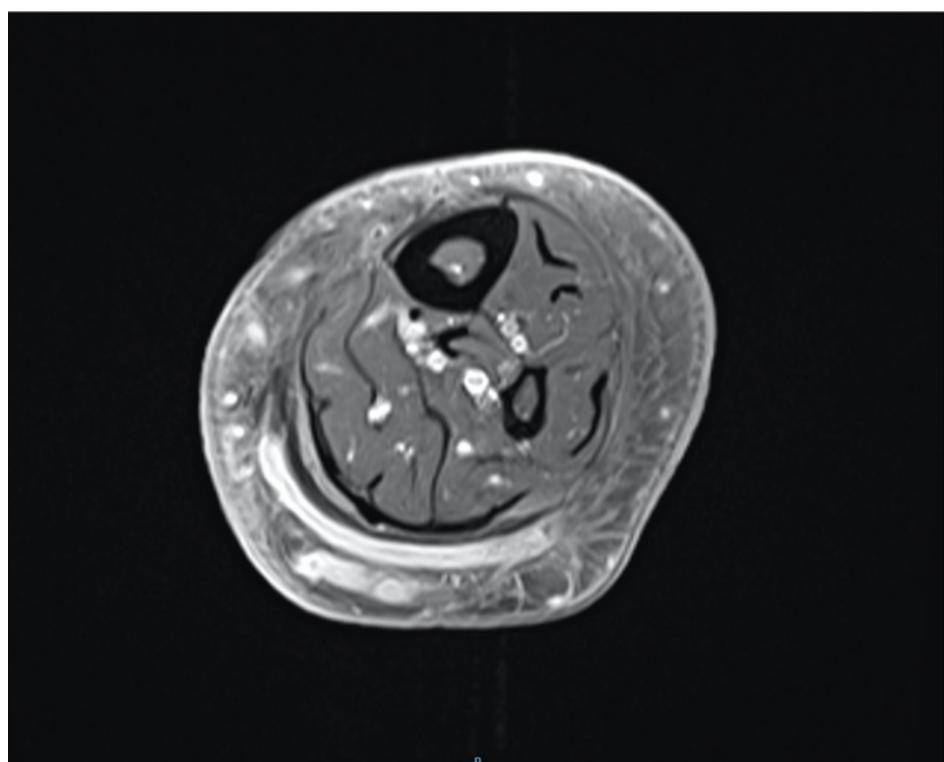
Axial T1-weighted MR image showing a sinus tract that crosses the midline to the lateral aspect of the left calf.
